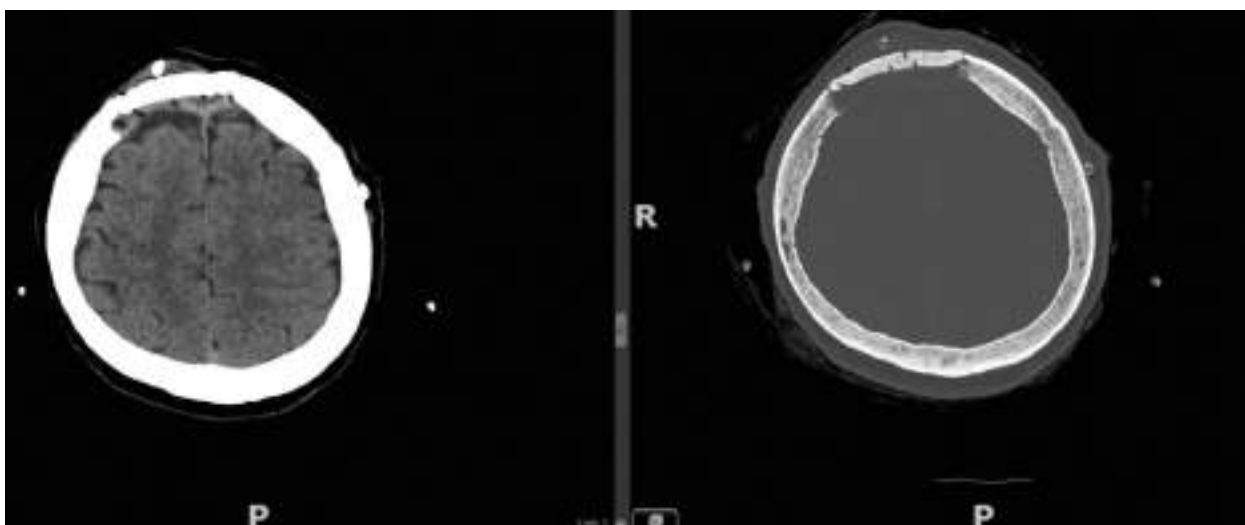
Postoperative endocranial CT – PMMA implant
